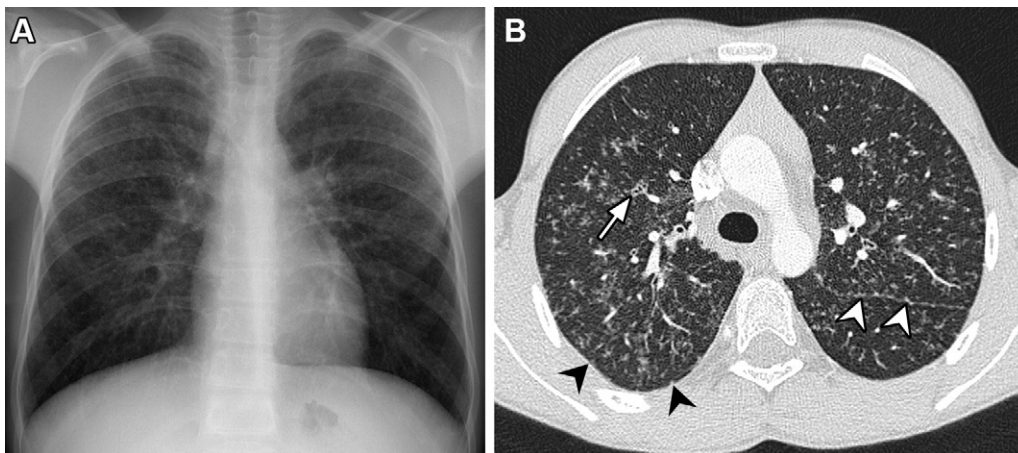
Pulmonary sarcoidosis in a 15-year-old adolescent boy. (A) Chest radiograph shows bilateral upper lobe-predominant micronodular opacities and left hilar lymphadenopathy consistent with stage 2 disease. (B) Axial chest CT image (lung window) shows micronodules with perilymphatic distribution through fissures (white arrowheads), interlobular septa, bronchovascular bundles (arrow), and subpleural nodules (black arrowheads).
